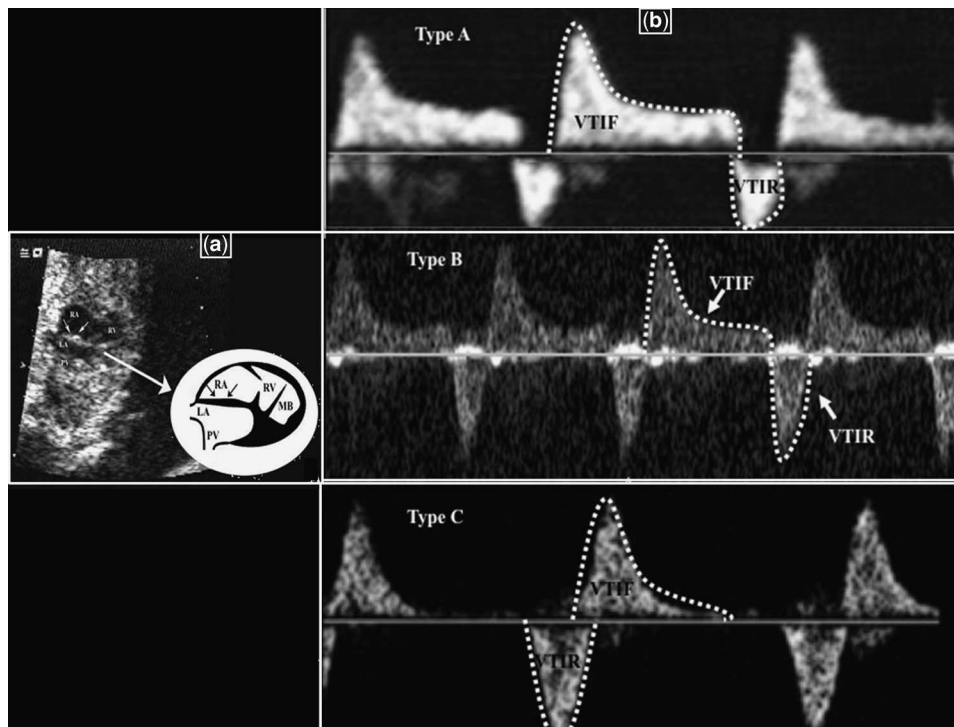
Transabdominal foetal echocardiogram. (a) Foetal 2D echocardiogram demonstrating thickened, intact inter-atrial septum in the presence of hypoplastic left ventricle at 28 weeks of gestation. (b) Foetal Doppler flow interrogation of the pulmonary vein showing three different pulmonary vein Doppler patterns (Type A, B, and C). Arrows = atrial septum; LA = left atrium; MB = moderator band; PV = pulmonary vein; RA = right atrium; RV = right ventricle.
